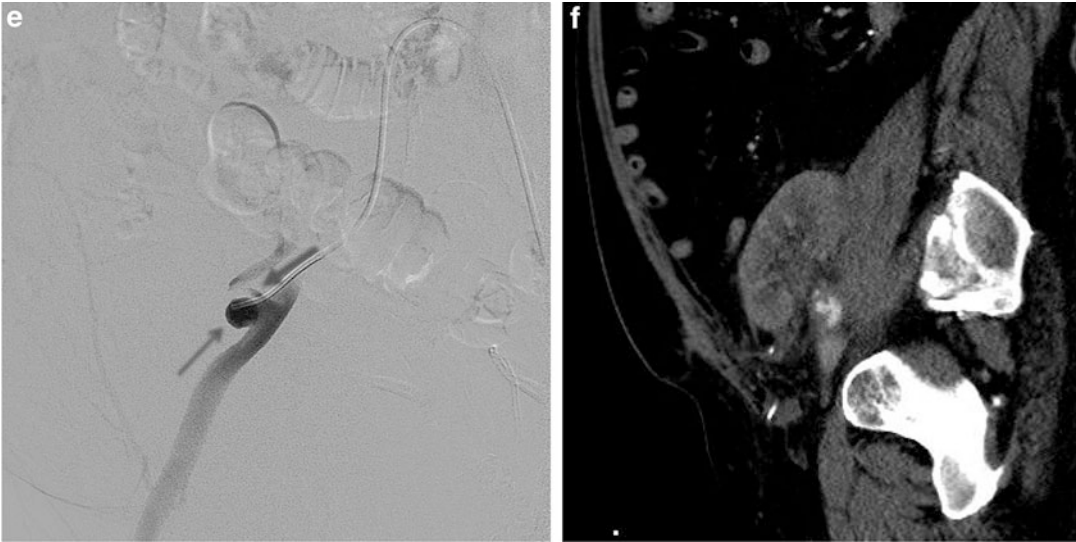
Arteriography in renal transplant artery stenosis. (a) The spectral Doppler tracing of the proximal, post-anastomotic renal artery reveals elevated peak systolic velocity (233 cm/s), which is more than double the velocity in the external iliac artery (not shown). (b) Oblique projection from a catheter-directed arteriogram shows narrowing in the proximal renal artery (*arrow*). (c) Magnified view in the oblique projection with superimposed luminal diameter measurements shows the relatively mild degree of stenosis comparing the stenotic diameter
